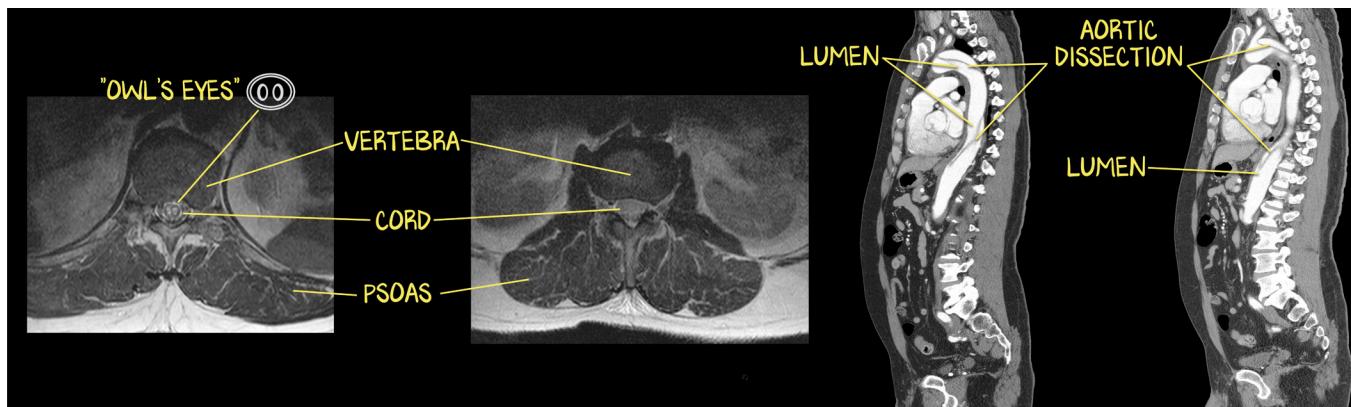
A look at Adamkiewicz Artery Syndrome Through Radiographs
